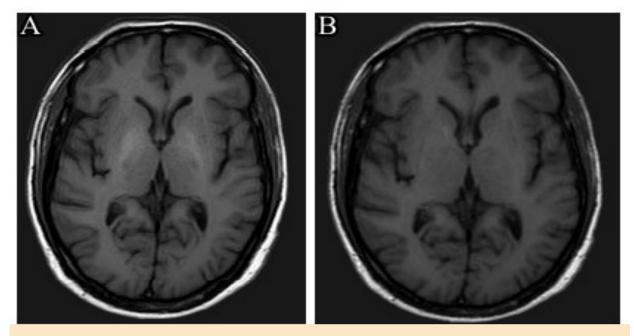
Axial T1-WI MRI (A) pre-transplantation showing high signal intensity (grade 2) in globus pallidus and (B) post-transplantation showing loss of signal intensity (grade 0).
